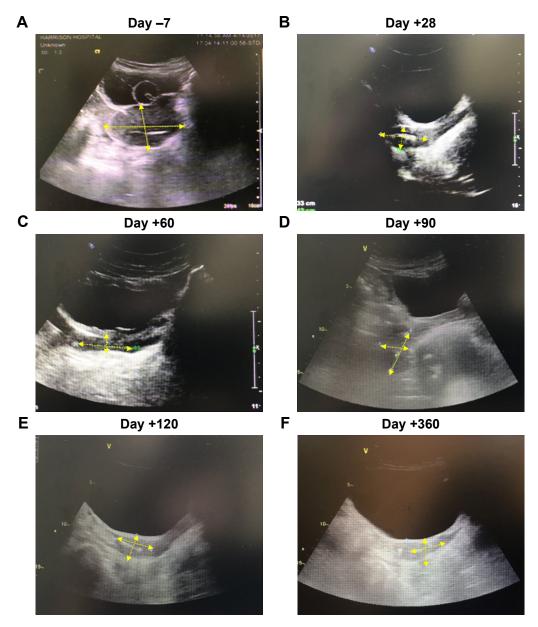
Pelvic ultrasound results of the patient before and after CAR T-cell therapy.
